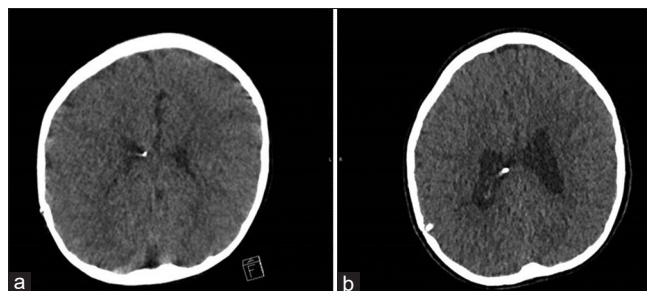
Comparison of computed tomography (CT) imaging. (a) baseline CT scan demonstrating baseline ventricular caliber. (b) CT scan at time of presentation with ventricular dilation.
